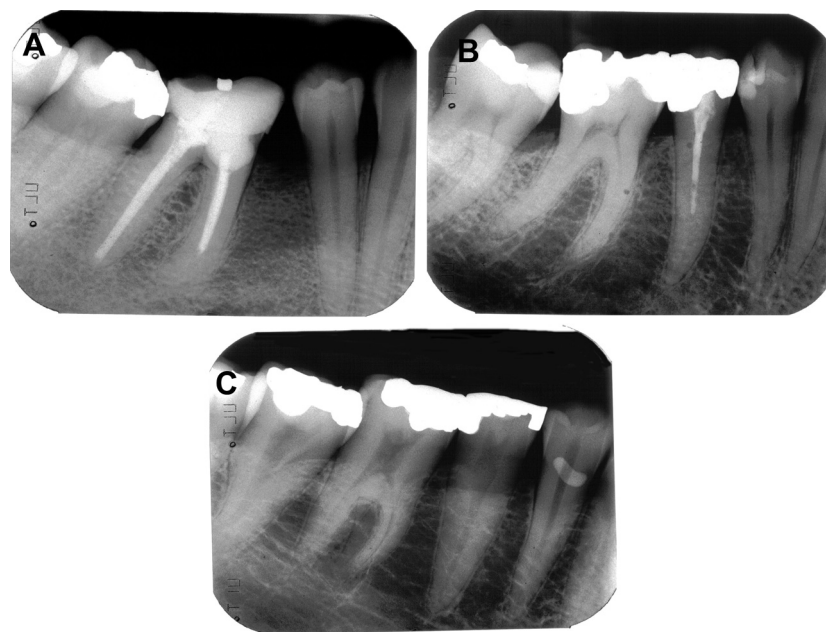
Reference images. The radiographs present dense trabeculation with small intertrabecular spaces (A), mixed dense and sparse trabeculation with small intertrabecular spaces cervically and larger spaces more apically (B), and sparse trabeculation with large intertrabecular spaces and almost invisible trabeculae (C).
